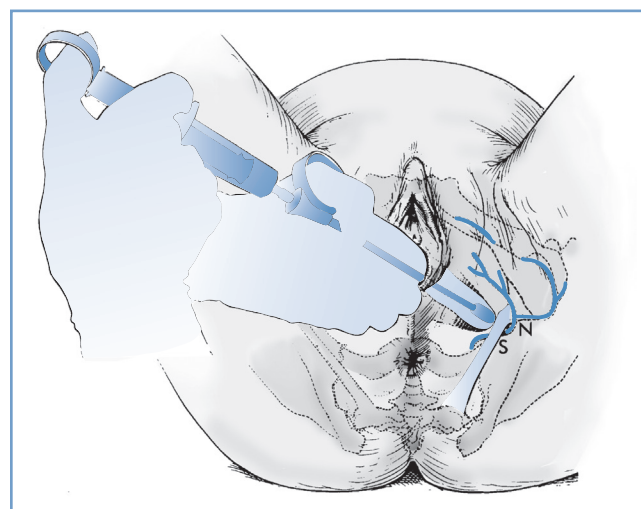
■ Local infiltration of the pudendal nerve. Transvaginal technique showing the needle extended beyond the needle guard and passing through the sacrospinous ligament (S) to reach the pudendal nerve (N). (From Cunningham FG, MacDonald PC, Gant NF, et al. *Williams Obstetrics*. 20th edition. Stamford, CT, Appleton & Lange, 1997:389.)
